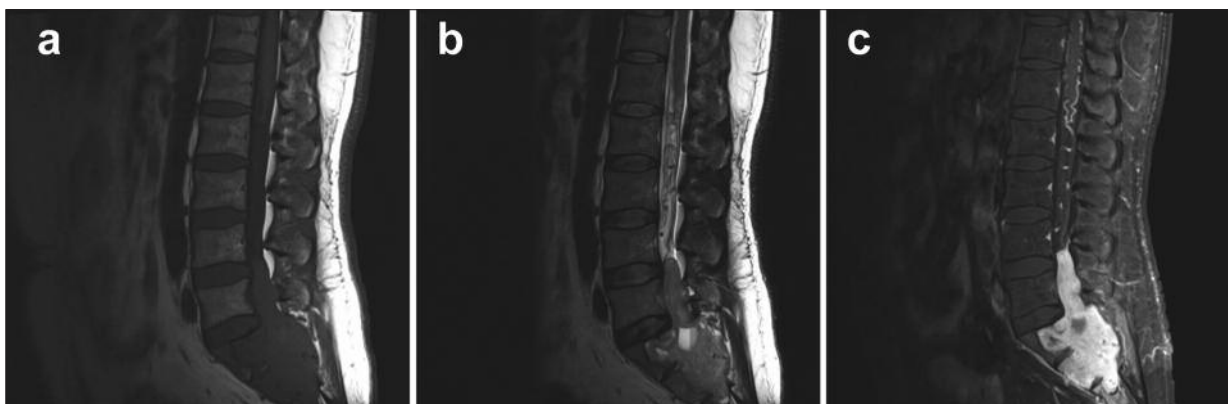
a*, Sagittal plain T1-weighted, *(b)* plain T2-weighted, *(c)* T1-weighted with contrast MRI of the lumbosacral spine showed a sacral tumor isointense to paravertebral muscles on T1-weighted MRI and hyperintense on T2-weighted MRI with heterogeneous enhancement.
